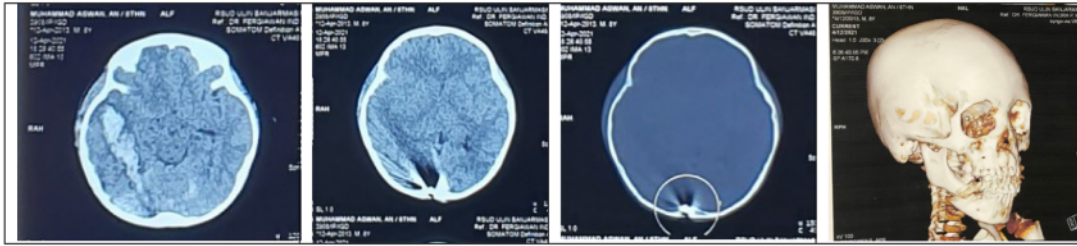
Head CT-Scan Bone Window and 3D bone showing defect and fracture with entering bullet from frontal lobe, the bullet trajectory passed through the Right temporal pole, right temporal lobe, right occipital cortex, and ended at right sinus transversus.
